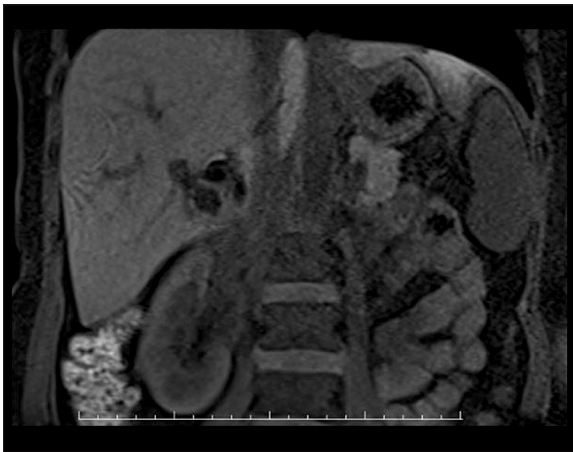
MR imaging shows a heterogeneous hypointense lesion hilum in the liver on coronal T1 fat-suppressed sequences.
